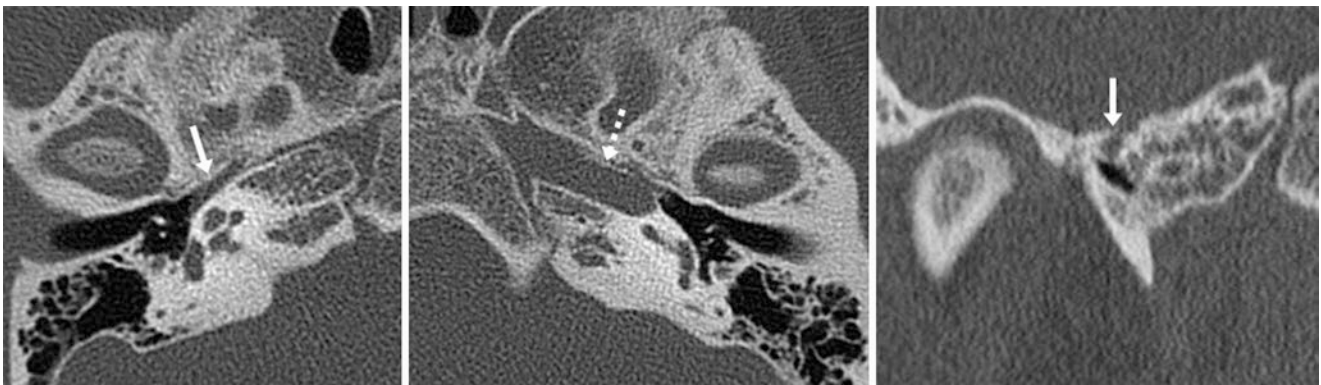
14-year-old with a hypoplastic right ICA bony canal (arrows) on a temporal bone nonenhanced CT with axial (left) and coronal (right) images in bone windows, performed for bilateral hearing loss. (The etiology was unknown, as the examination was otherwise negative.) Note the normal, contralateral left ICA and bony canal (dotted arrow)
